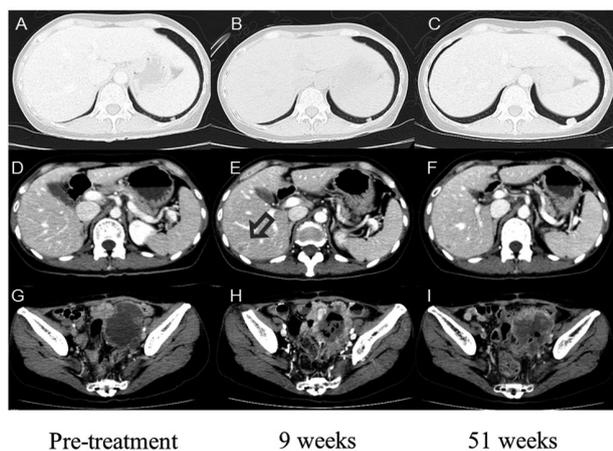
CT images during pazopanib treatment. At nine weeks from the initiation of pazopanib treatment, a new lesion in liver was detected (E, shown by arrow). At 51 weeks, pelvic and lung tumors increased in size (C and I), however, liver tumor further decreased in size (F). A, B, C: lung tumor; D, E, F: Liver tumor (D: no tumor at pre-treatment); G, H, I: pelvic tumor; A, D, G: images at pre-treatment; B, E, H: images at nine weeks; C, F, I: images at 51 weeks.
